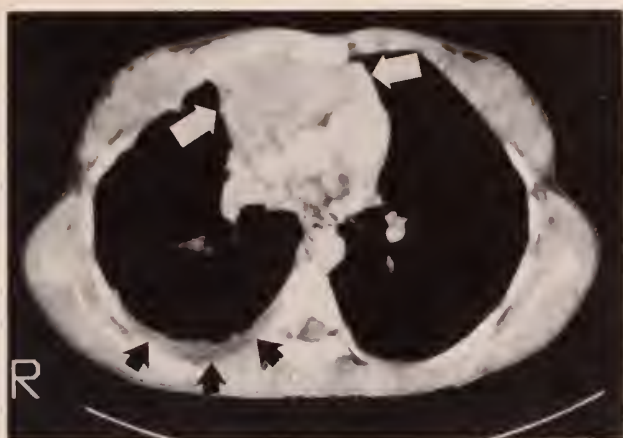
Cross section CT scan at the level indicated in Figure 2. Note the pleural fluid layering posteriorly (black arrows) and the large mediastinal mass (white arrows).
